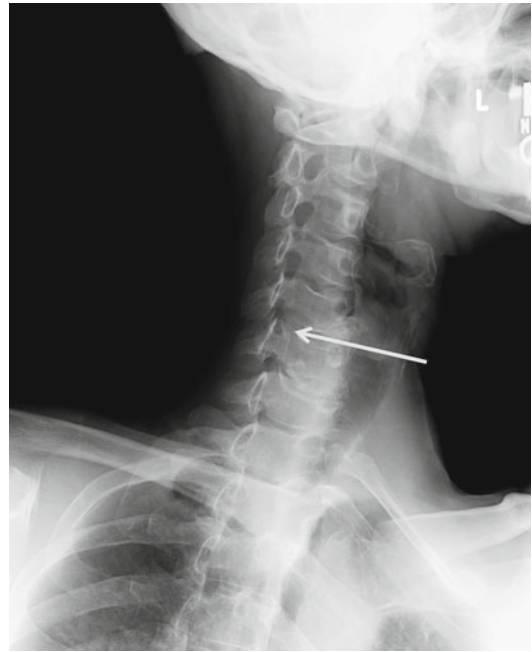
Plain oblique radiograph demonstrating uncovertebral osteophytes causing foraminal narrowing C5-6 (arrow)
